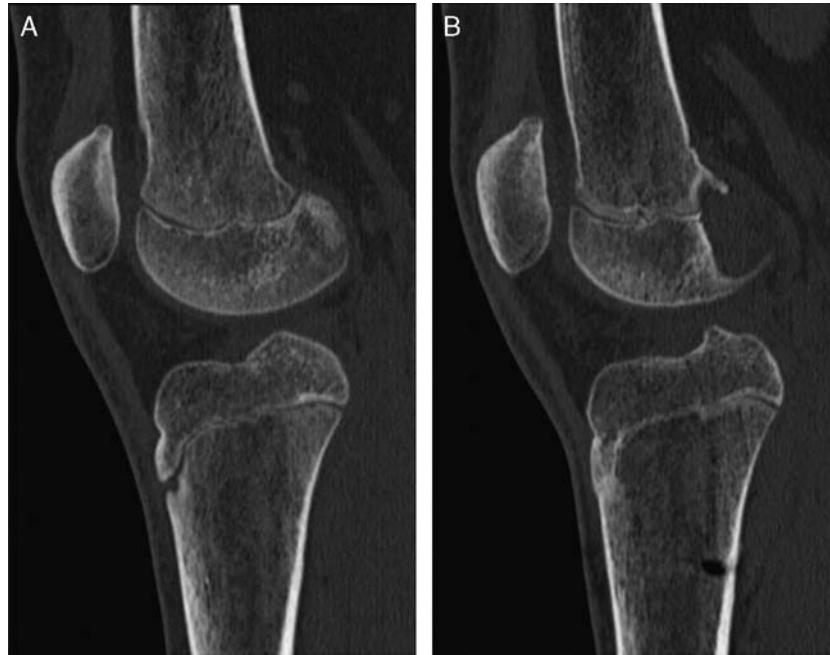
Computed tomography sagittal cut showing an open tibial tubercle apophysis in the unaffected extremity (A), compared with a completely fused tibial tubercle apophysis in the affected extremity (B).
